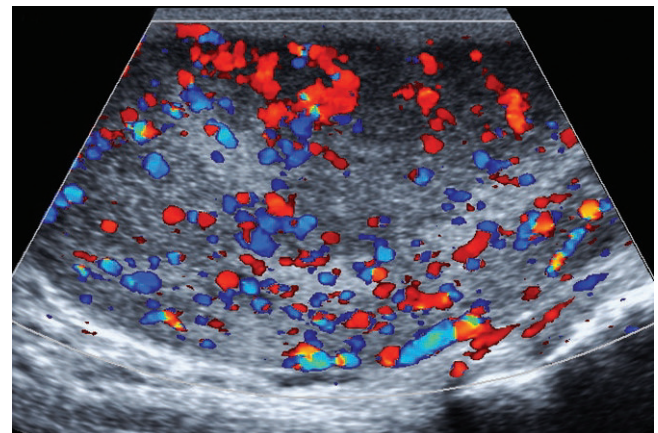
The longitudinal color Doppler sonographic image of the testis shows marked hypervascularity of the tumor.
